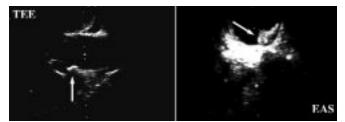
An atherosclerotic plaque in the posterior wall of the ascending aorta (arrows) visualized by transesophageal echo (TEE) and epiaortic scanning (EAS).
